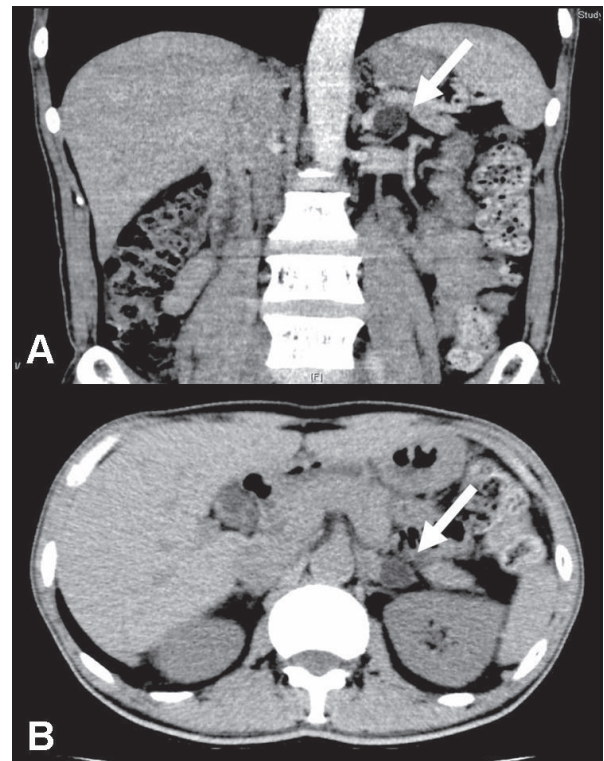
(A) Coronal view and (B) axial view of contrast-enhanced abdominal computed tomography revealed a 1.5 × 1.3 × 1.6-cm well-circumscribed hypodense mass (white arrow) on top of the left adrenal gland.
